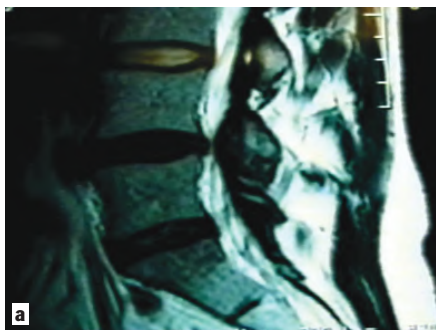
This sagittal MRI demonstrates two dark discs on T2 imaging, but does not show significant disc protrusion or the presence of an HIZ. It could be interpreted as "normal." Positive evocative discography identified a painful grade IV annular tear.
